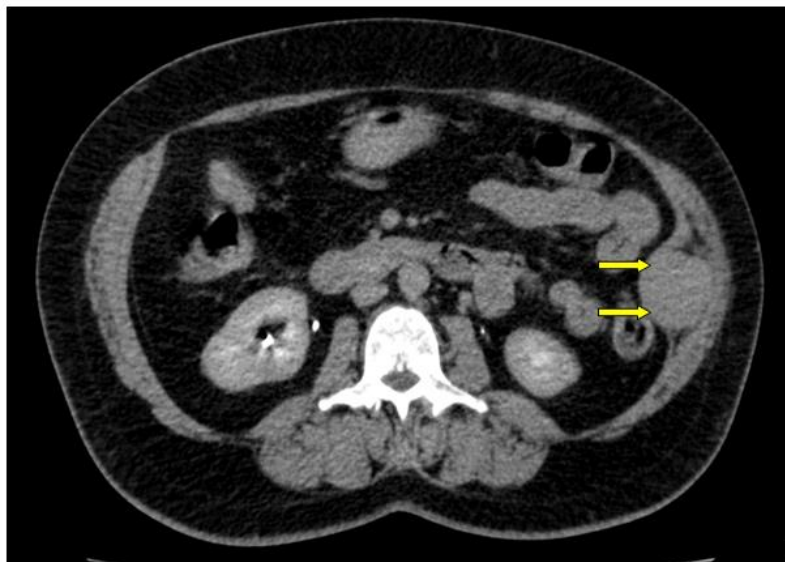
(a, b): Abdominal CT scan with PDC injection; late phase (a: axial section, b: coronal section) late washing (arrow)
